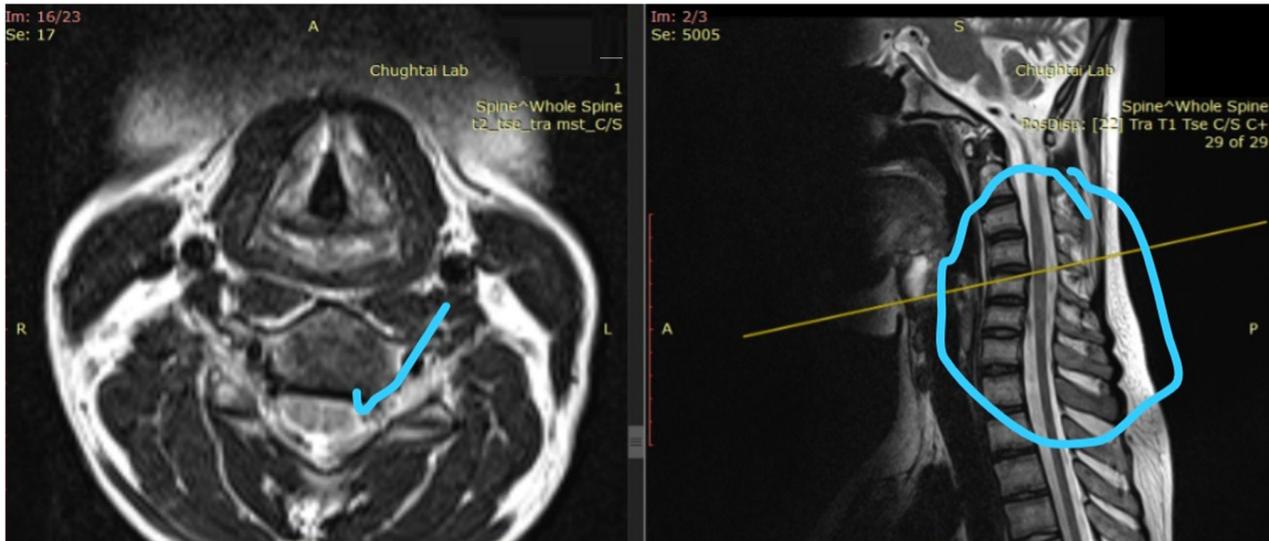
MRI indicating a few hyperintense signals (blue circle) in the cervical cord at the C3, C4 and C5 levels.
